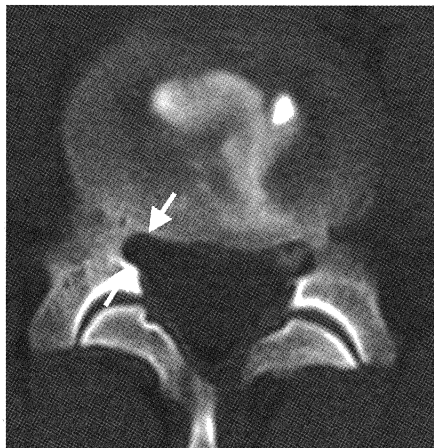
Post-discographic computed tomogram of the L5 pedicle level showing right lateral recess stenosis with 3 mm of anterior-posterior distance (arrows), compared to 4 mm anterior-posterior distance of the left side.
